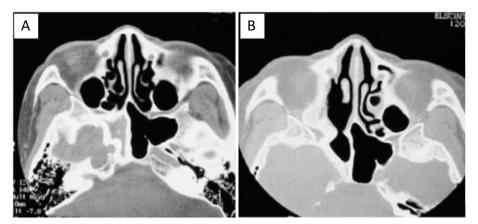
Case 2. Right sphenoid sinus fungal ball. CT scan coronal view (A left) revealing a complete hypodense filling of the right sphenoid sinus associated with a regular thickening along the bony walls of the sinus with central hyperdensity. Postoperative CT scan (B right) of a transethmoidal approach to the right sphenoid sinus
